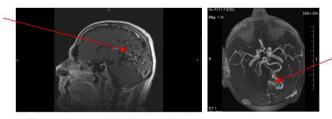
MRI of the brain of patient K. Arteriovenous malformation is indicated by red arrows.
